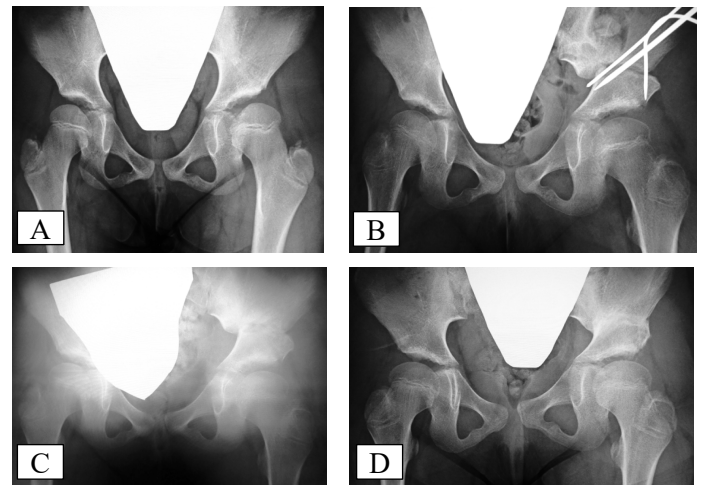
A case presentation: preoperative radiograph (13A), radiograph taken at 6 weeks postoperatively after a spica cast removal (13B), radiograph taken 9 weeks postoperatively after removal of hardware (13C), radiographs taken at 12 weeks postoperatively after final union (13D).
